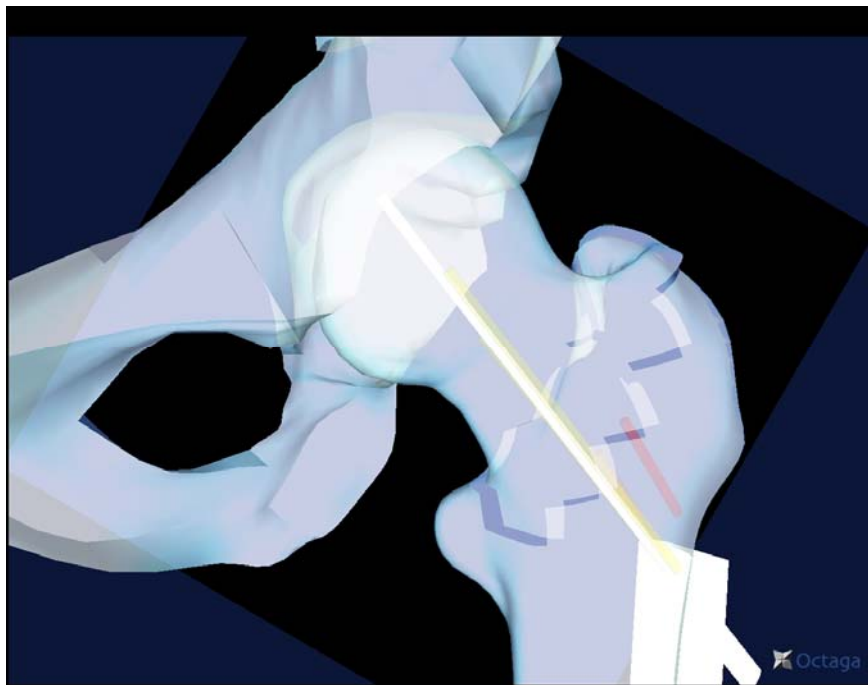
Mistakenly placed guide-holes are visible as coloured drill-tracks on this virtual x-ray. The first drill-track is red, the second is orange, and the third is yellow.
